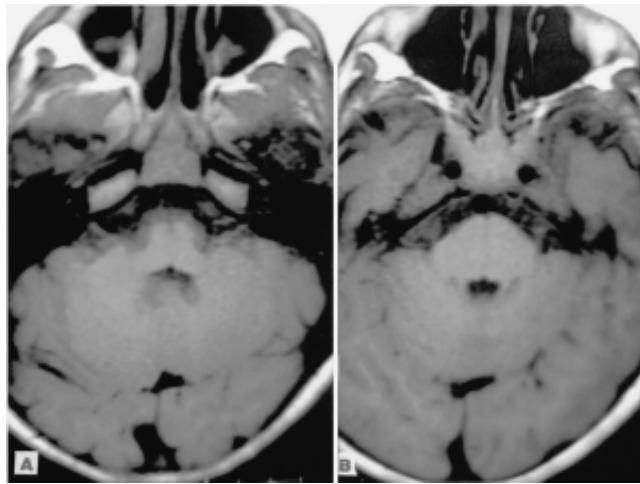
MRI scans without contrast material obtained almost 10 months after the onset of the neurological complication. Both of them studies shows a mass laminate due, possibly, to meningeal thickening or chronic leptomeningitis in the pontine cistern and almost stuck to the medulla oblongata and pons.
